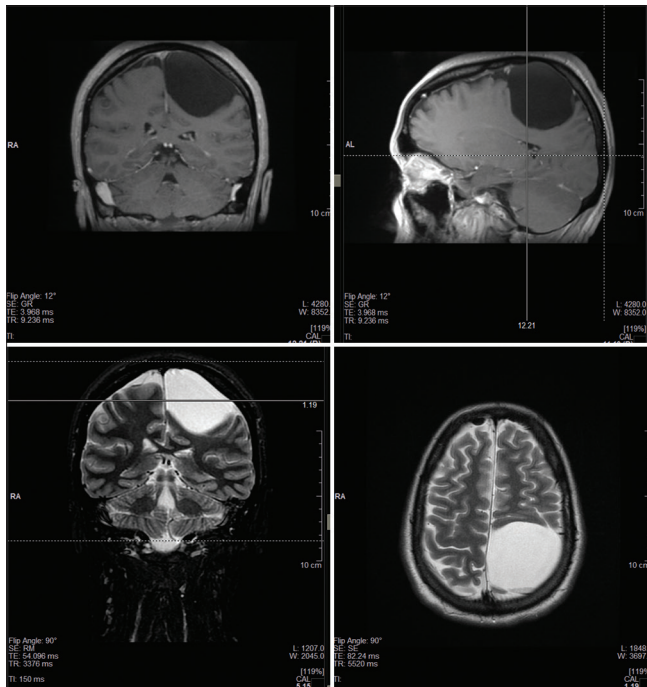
Preoperative magnetic resonance imaging examination shows a nonenhancing extra-axial cystic lesion in left frontoparietal convexity, hypointense on T1-weighted, and hyperintense on T2-weighted sequences
